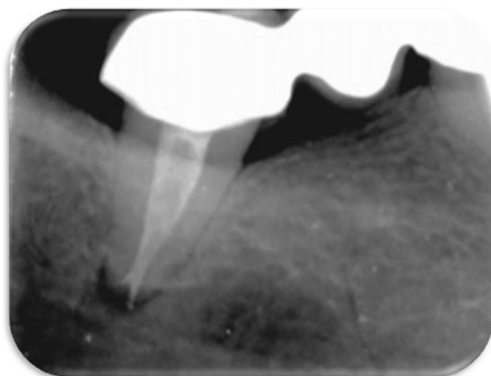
Case #2 final radiograph following the completion of the double-wavelength laser-assisted treatment. To be noticed are the isthmuses between the two main canals and the apical delta completely debried and sealed
